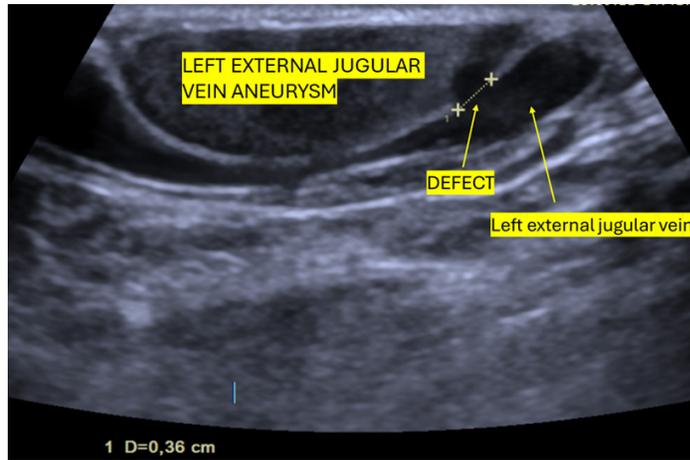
Color Doppler ultrasound showing the left external jugular vein saccular aneurysm.
